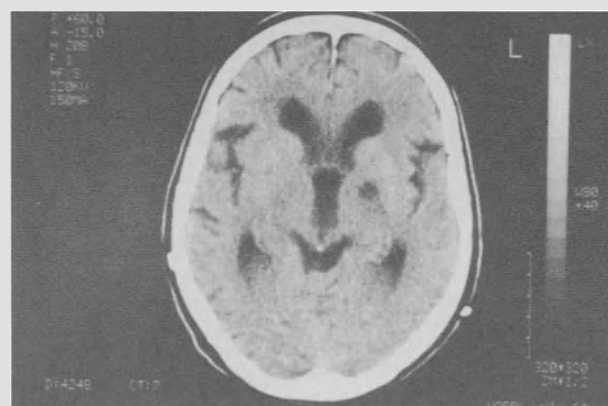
CT scan showing a one week-old left pallidal RF lesion in a patient with dilated ventricles. The pallidal lesion lies 21 mm lateral to the midline of the third ventricle, and extends into the internal capsule
